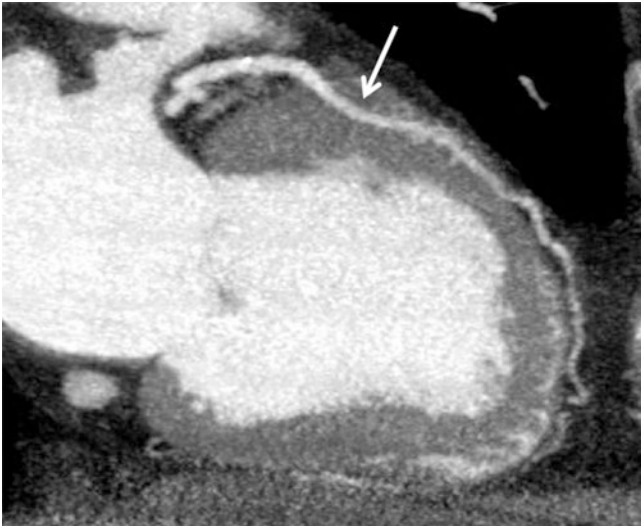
CAD-RADS reporting categories. Curved planar and MPR images from coronary CT studies performed on ED chest pain patients show (a) CAD-RADS1, no luminal stenosis in the RCA; (b) CAD-RADS2, calcified and non-calcified plaque causing 1–24% stenosis of the LAD; (c) CAD-RADS3, mixed plaque causing 25–49% stenosis of the LAD; (d) CAD-RADS4, calcified plaque causing
